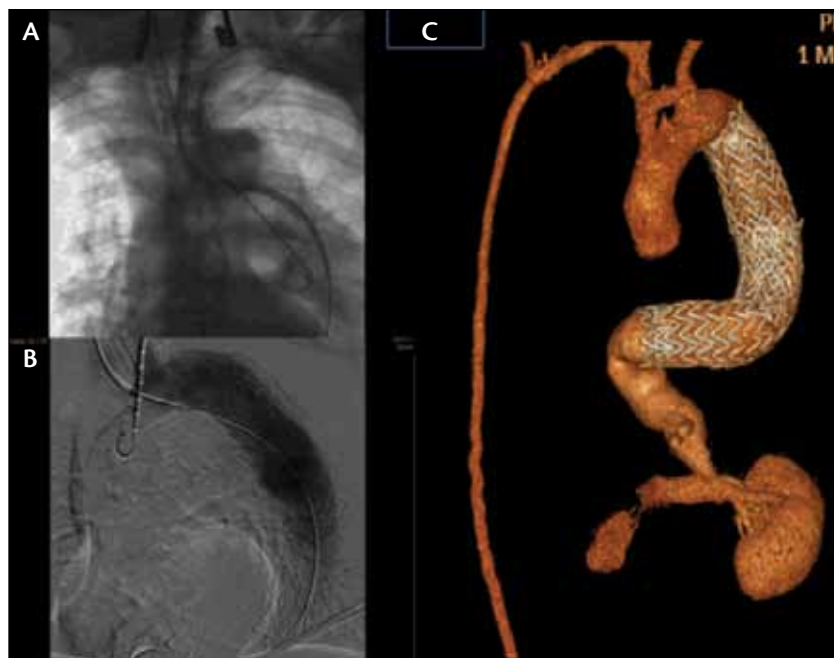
Intraoperative angiography showing left carotid access (A). Note that the sheath is already advanced from the left carotid artery up to the level of the descending aorta. Final angiography demonstrating exclusion of the TAA (B). Three-dimensional CT reconstruction of the entire aorta showing aortic interruption at the level of the renal arteries (C).
